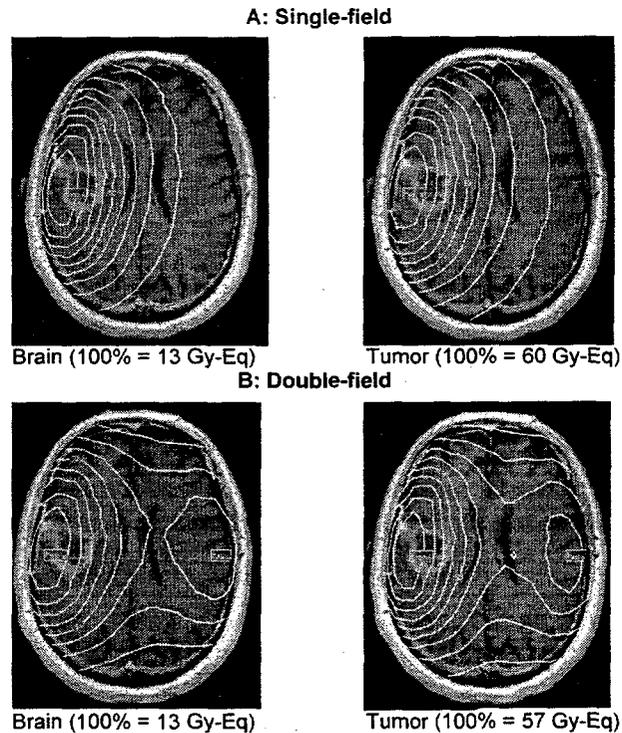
Isodose contours for normal brain (left panels) and tumor (right panels) resulting from treatment plans employing single- (A) or double-field (B) irradiations. The isodoses (at 10% interval) are superimposed on transaxial sections of MRI scans of head. The tumor volume is defined as the contrast enhancing volume.
